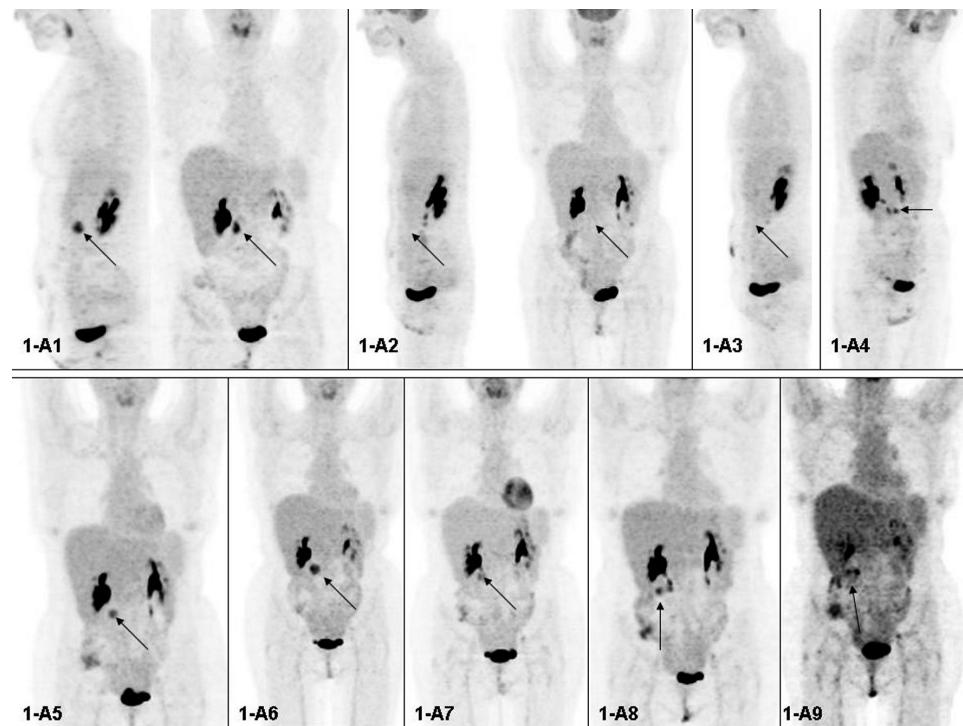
In this figure maximum intensity projection images of all F18-FDG-PET/CTs are reported; in particular Figure 1-A1 reports left lateral and anterior views of the study performed in 2006, showing the lesion (arrows); Figure 1-A2 and Figure 1-A3 report left lateral and anterior views of the negative studies performed during 2007; Figure 1-A4 shows the site of disease in a 30° right oblique view of the study performed in 2008; Figure 1-A5 reports the anterior view of a study performed in the same year where the persistent pathologic uptake is visible; Figure 1-A6 shows the anterior view of the study performed in 2009 revealing diseases progression (arrow); Figure 1-A7 shows the anterior view of the study performed in 2009 after radiotherapy documenting an uptake reduction; Figure 1-A8 and Figure 1-A9 show anterior views of the studies performed at the end of 2009 and at the beginning of 2010 revealing disease relapse and progression.
